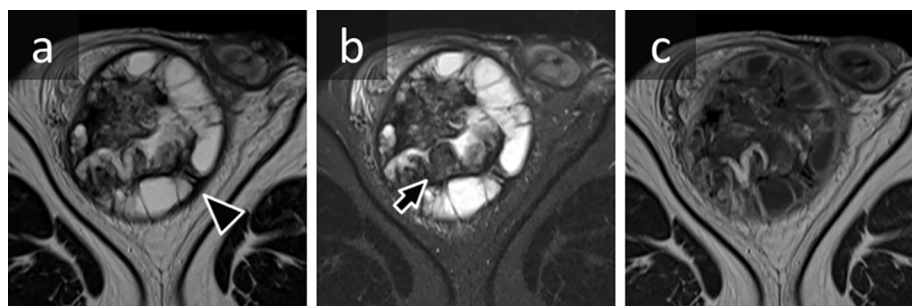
Magnetic resonance imaging of the scrotum. (a) In the T2-weighted image, a coating and a partition wall (arrowhead) showing low signal were observed. (b) In the fat suppression image, fat components (arrow) were observed. (c) The contrast effect was confirmed.
